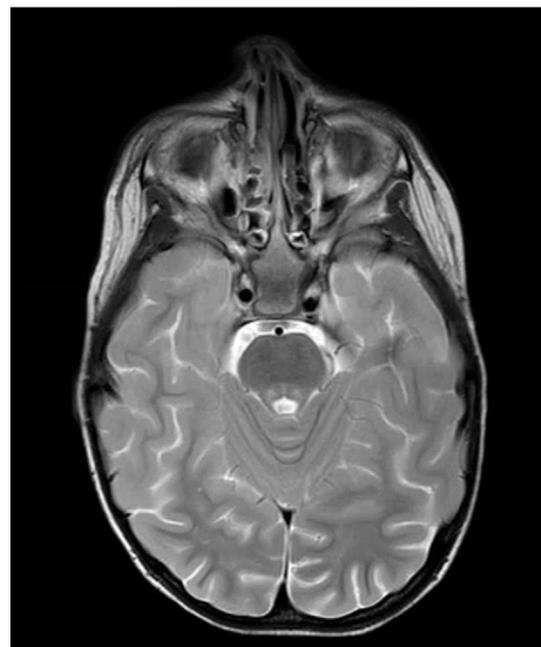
MRI of brain, T2W_TSI image. Symmetrical changes in the dorsal part of pons with inhibition of diffusion at colliculus facialis.
